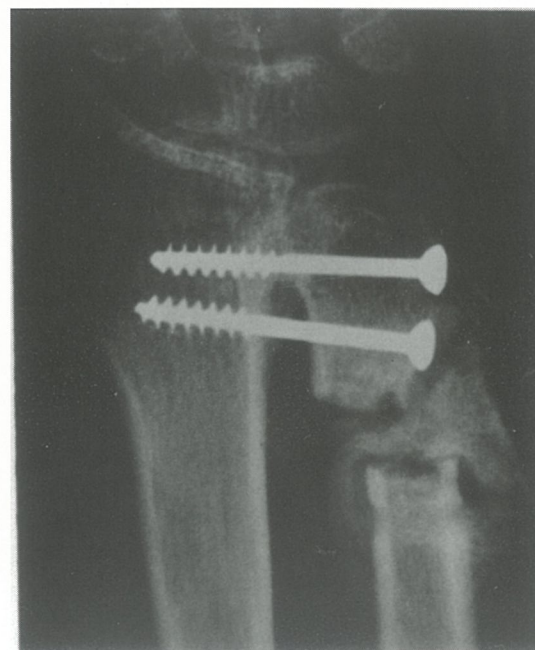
Radiograph at 8 weeks after Sauve-Kapandji operation showed excessive bone filling the gap created at the distal ulna resulting in forearm being fixed in mid prone position.
